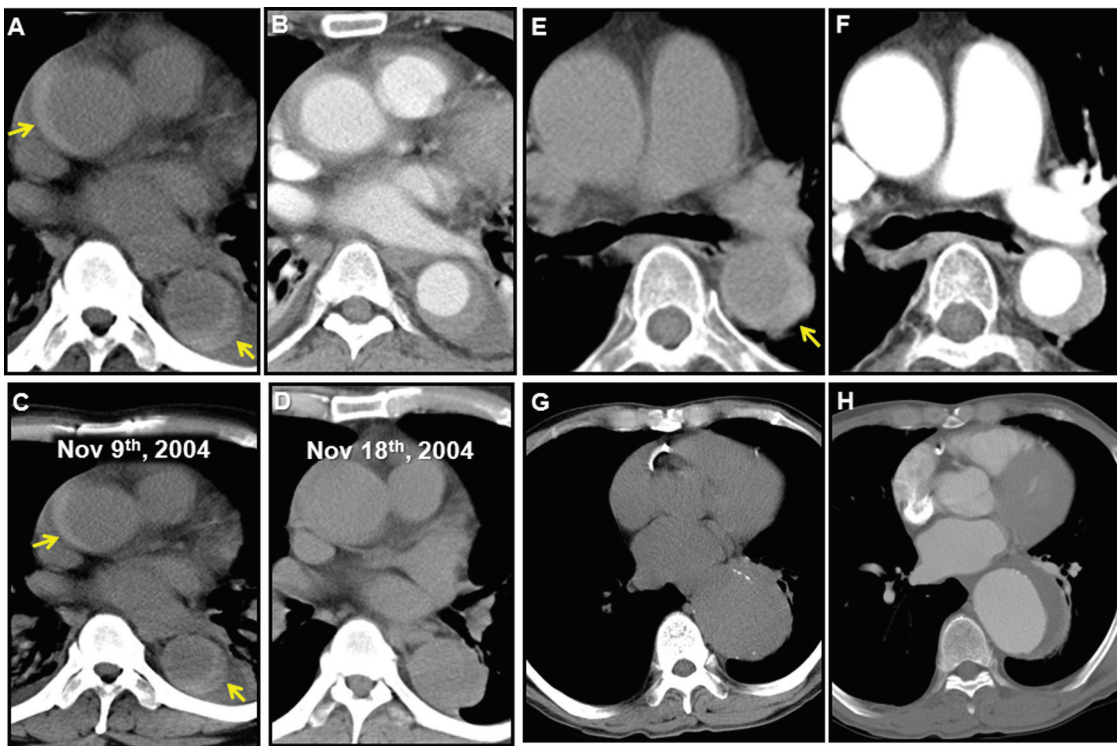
Representative computed tomography (CT) images showing characteristic ‘high attenuation’ in aortic intramural hematoma before contrast injection. On pre-contrast CT (A), high attenuation areas along the aortic wall (yellow arrow) represent intramural hematoma. These areas did not show any contrast enhancement after injection of contrast medium (B) and disappeared within 2 weeks after symptom onset (C and D). Attenuation before contrast injection is helpful for the differential diagnosis of eccentric aortic wall thickening, as this phenomenon occurs in a patient with intramural hematoma (E and F), not in a patient with dilated aorta and crescentic mural thrombus (G and H).
